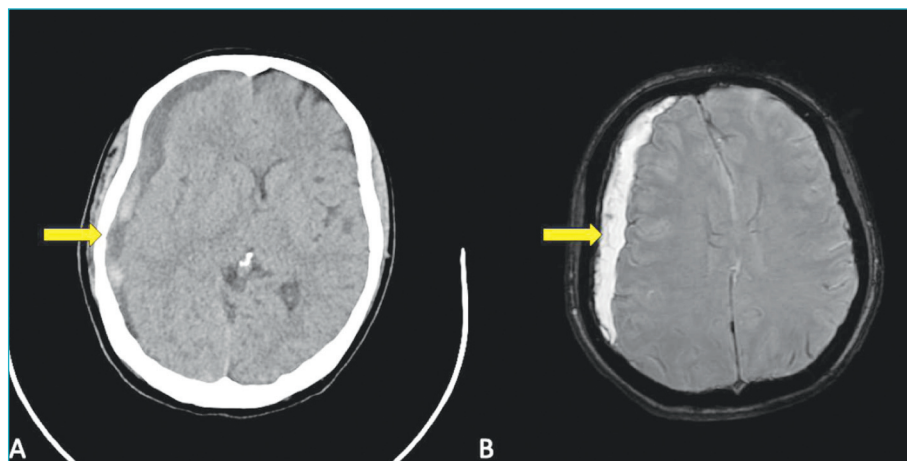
Cranial computed tomography (A) and magnetic resonance imaging (B) scan show the right sided subdural hematoma with midline shift.
